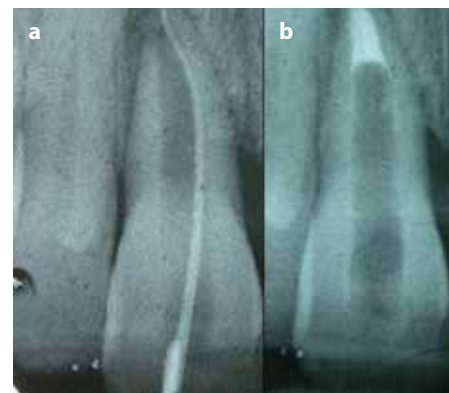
(a) Working length radiograph for UR1 with very wide root canal. (b) Orthograde placement of apical MTA plug.
